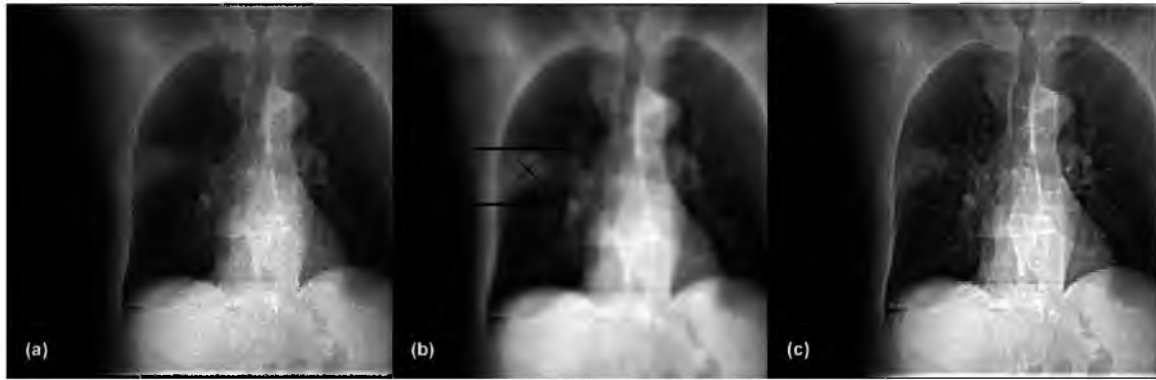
Reconstructed 4D radiograph sequences through a lung tumor patient breathing cycle for radiograph with (a) a 230 MeV proton pencil beam, (b) a 330 MeV proton pencil beam, and (c) a 500 MeV/nucleon carbon ion pencil beam. Please note: These sequences must be visualized using a PDF reader software with sequence display capabilities such as Adobe Acrobat™ in order to fully appreciate the motion.
